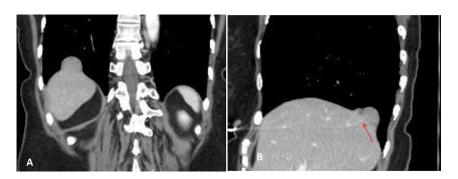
(A) Coronal CT demonstrating the "hump" and "band" sign. (B) Sagittal CT of the liver demonstrating a portal vein extending into the herniated liver parenchyma (arrow).
